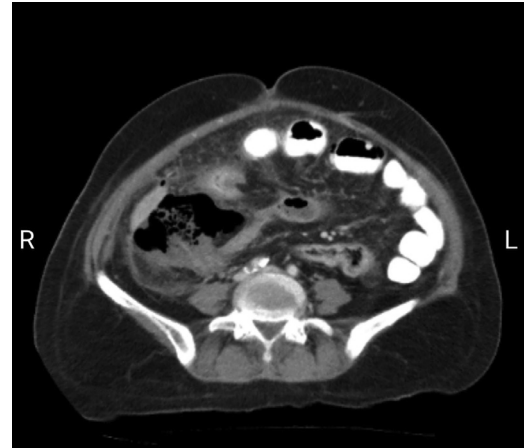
Portal phase post abdominal CT scan demonstrates cecal wall infarction defect with pneumoperitoneum and free fluid.
